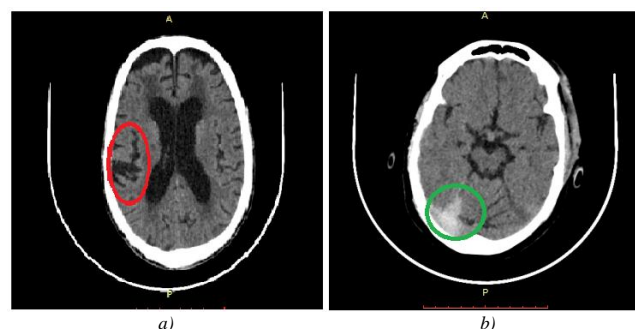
CT image of (a) ischemic, b) haemorrhagic stroke
